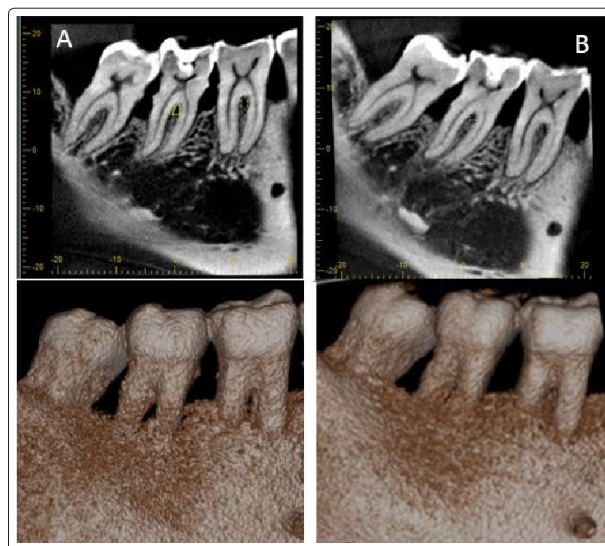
A) Initial CBCT of Interradicular areas of first and second molars. B) CBCT after six months of PRF treatment
